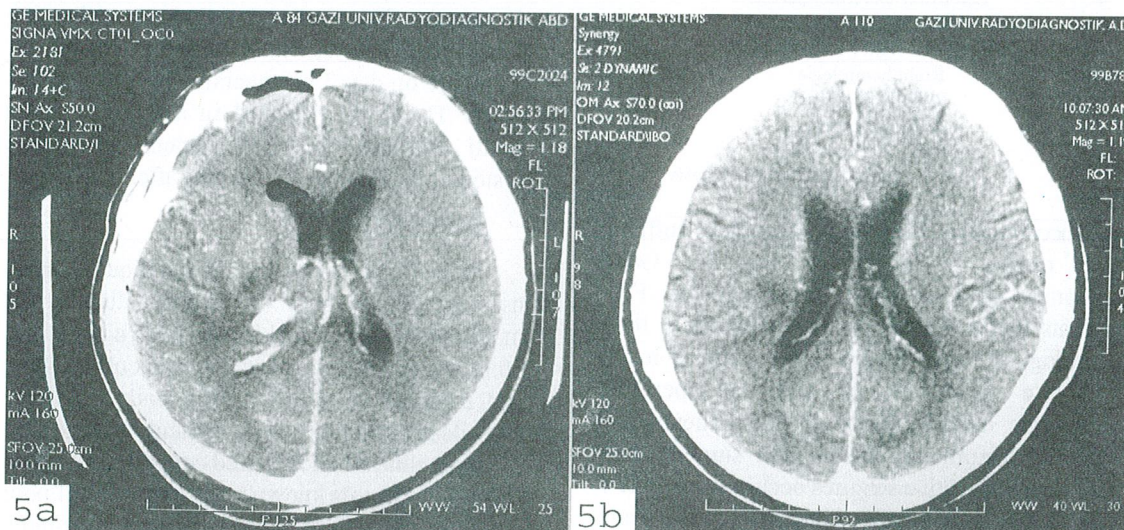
Immediate postoperative CT image showing microsurgical total resection of the lesion and a silicon drainage catheter. Since the diagnosis indicated an abscess, we positioned a silicon drainage catheter postoperatively for 3 days (A). No sign of abscess was seen on 3-month follow up CT (B).
